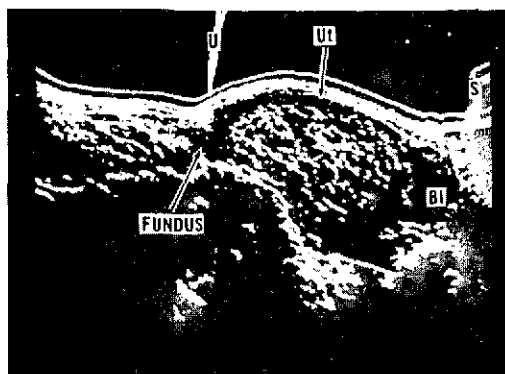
Sonograms showing several types of abnormal pregnancies. Top, from left: hydatidiform mole; double gestational sacs (10 weeks), with subsequent abortion. Bottom, from left: abnormal gestation (9 weeks); anencephaly (26 weeks). (See Figures 7 and 14 for abbreviations.)
